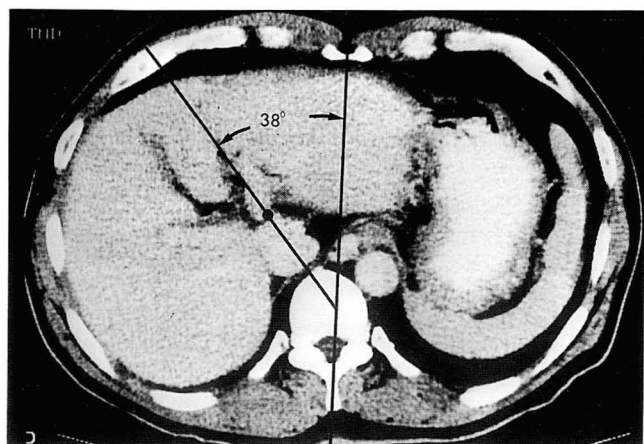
CT scan of a 60-year-old patient with liver cirrhosis shows the lateral displacement and counterclockwise rotation of the umbilical portion of the left portal vein and large LPVA (38°). ● ; umbilical point
